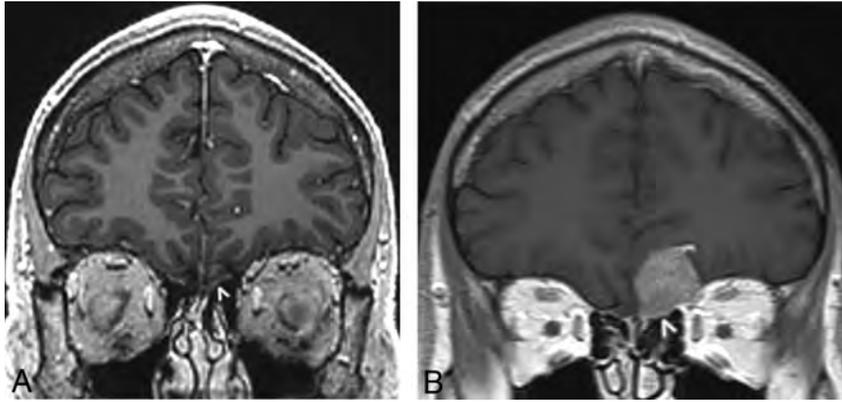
A 36-year-old man with a history of *IDHI* wild-type GBM centered in the corpus callosum, treated with radiation and TMZ (case 11). Coronal postcontrast T1-weighted echo-spoiled gradient echo image (A) obtained 1 year from initial treatment demonstrates abnormal enlargement and patchy enhancement of the left olfactory nerve (arrowhead). On a follow-up coronal postcontrast T1-weighted spin-echo image obtained 3 months later (B), the enhancing mass has enlarged (arrowhead) and appears to involve the leptomenigeal space, compatible with progressive recurrence.
